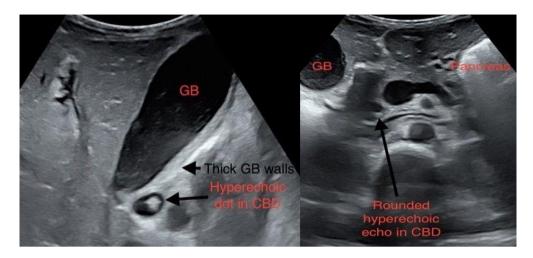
(A,B). Ultrasound shows hyperechoic nonshadowing dot surrounded by anechoic bile in CBD on transverse section (Bull's eye sign)
